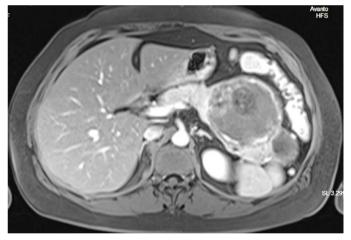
Abdominal MRI image of a rounded mass with lobulated contours, measuring approximately 11 x 8 x 7 cm.
